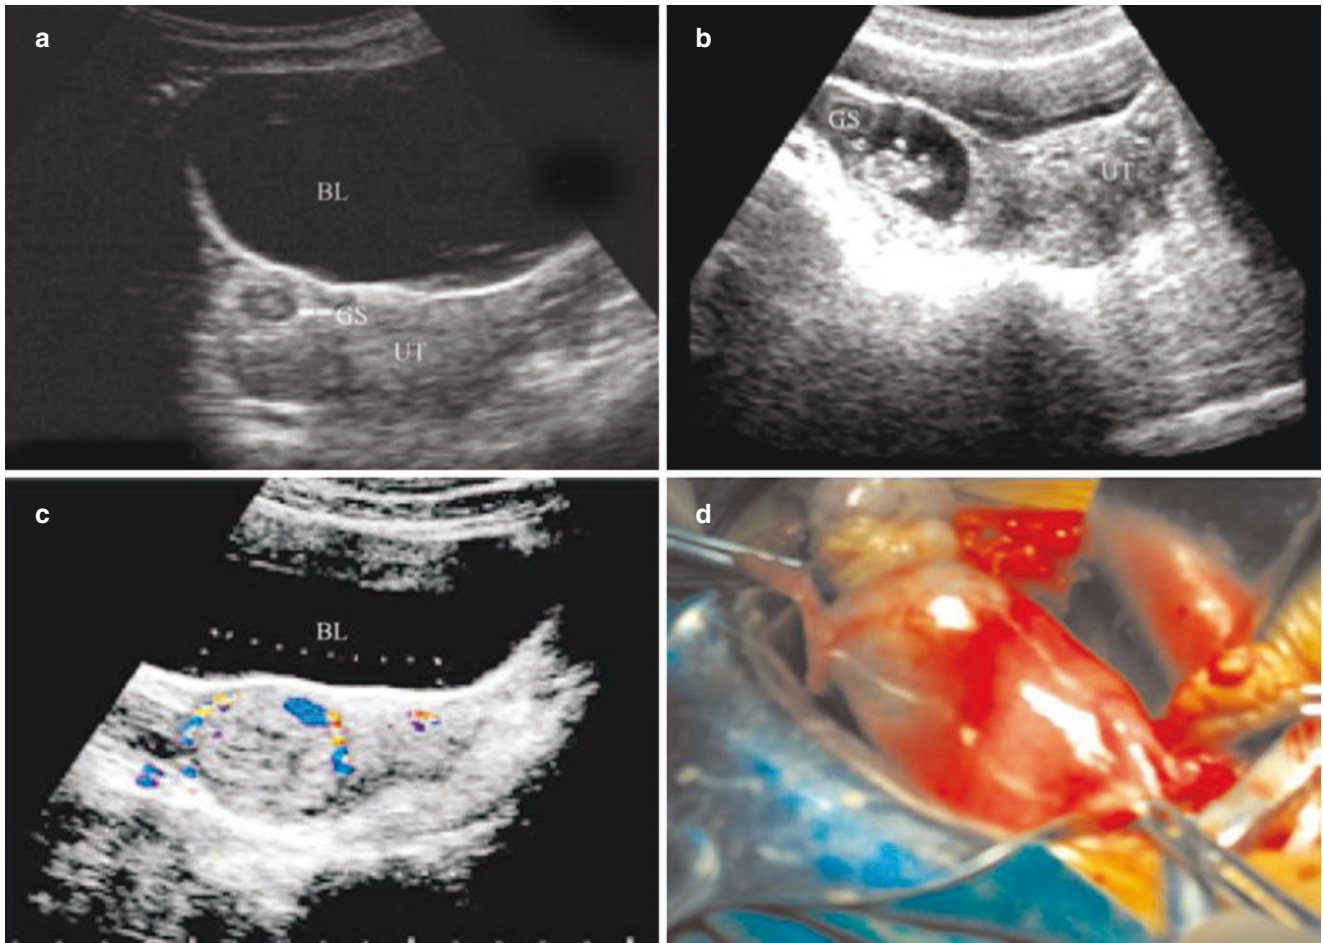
Interstitial pregnancy. (a). After 47 days of menopause, the patient had underwent contraceptive operation. After the operation, she had irregular vaginal bleeding for half a month. After three times of uterine curettage, she went to hospital for abdominal pain. Ultrasound examination shows a 3.0 cm × 4.3 cm × 4.1 cm hyperechoic mass in the right corner of the uterus, with a 0.8 cm diameter bubble-like anechoic area. Serum hCG is positive. (b). After 54 days of amenorrhea, there is no gestational sac in the uterine cavity.
